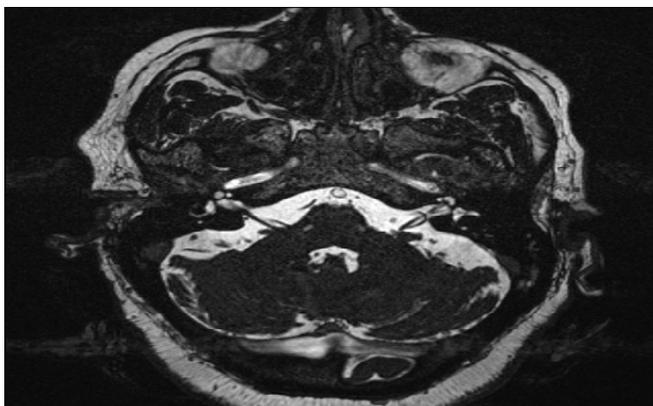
A brain MRI T2 3D CISS shows the blood vessel (i.e. artery) looped around the vestibulocochlear nerve on the left side.
